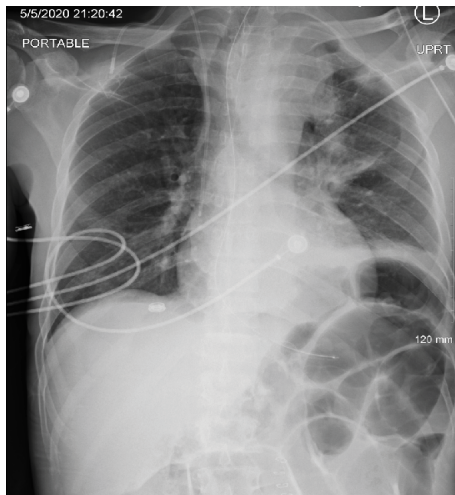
Chest X-ray showed superior mediastinal mass and left pulmonary opacities.
